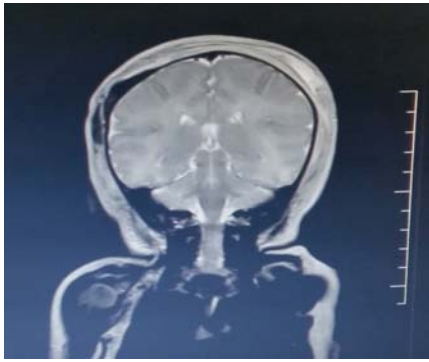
MRI showing subgaleal hematoma
